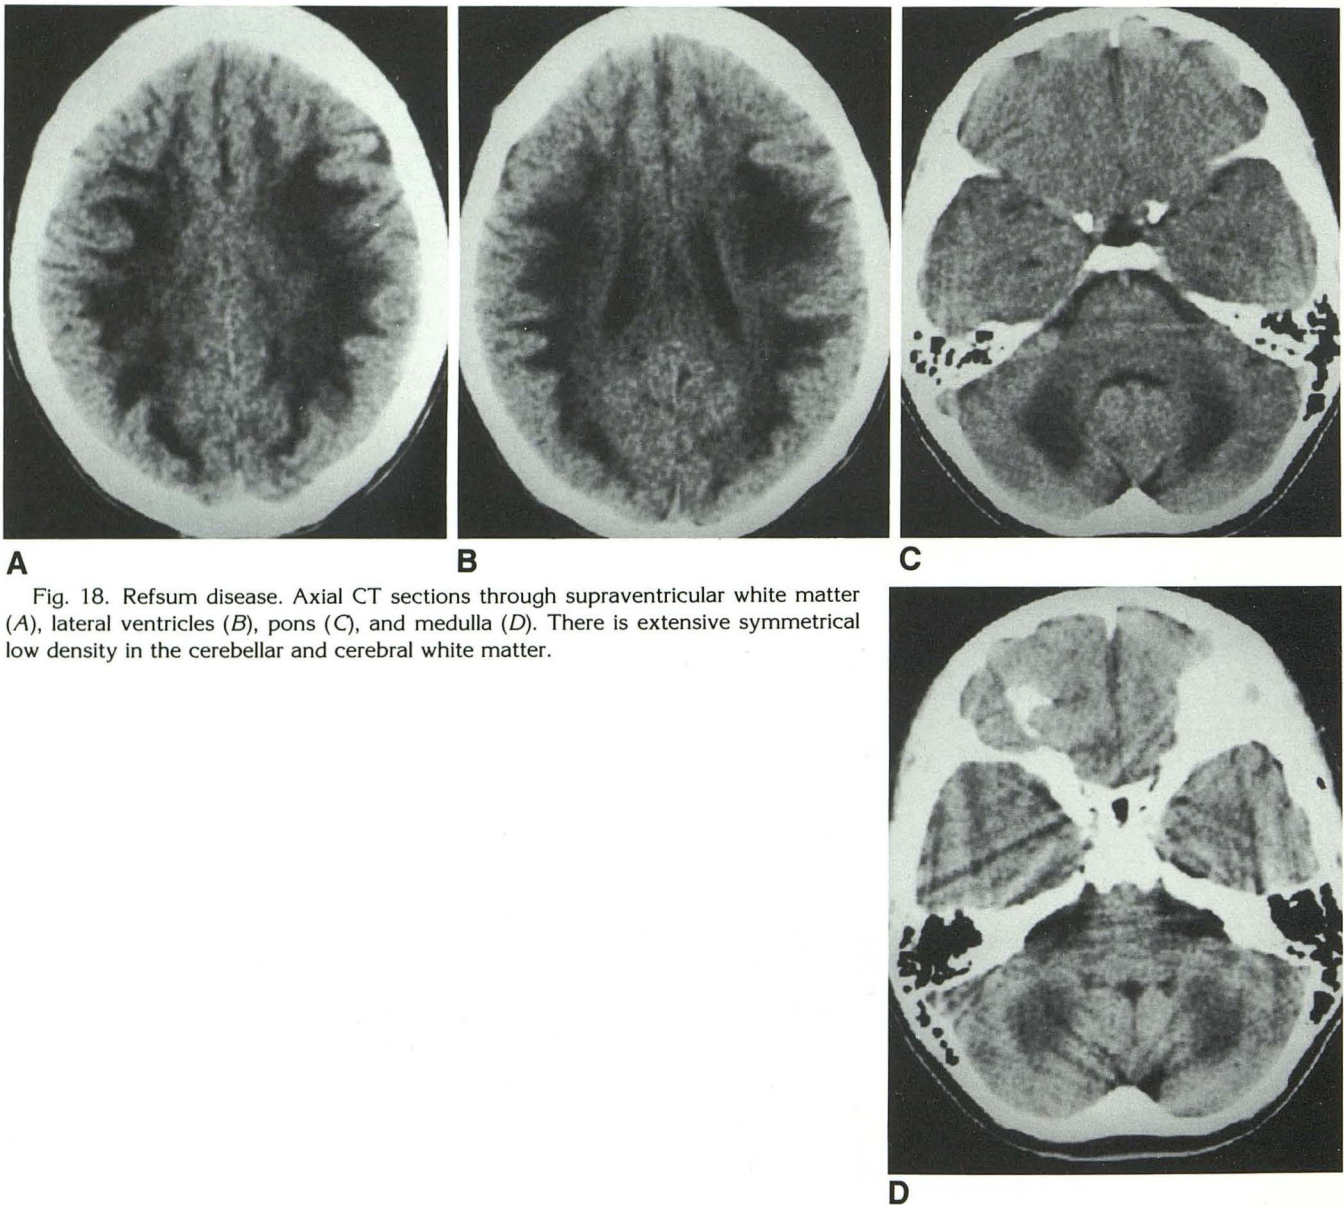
Refsum disease. Axial CT sections through supraventricular white matter (A), lateral ventricles (B), pons (C), and medulla (D). There is extensive symmetrical low density in the cerebellar and cerebral white matter.
